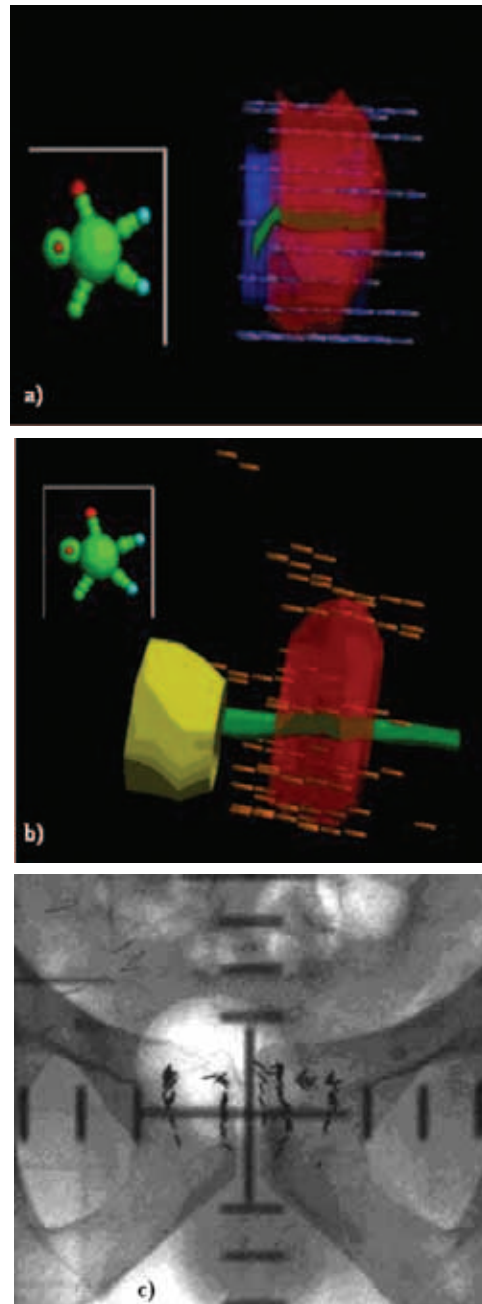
Distribution of seed types sources in: a) Pre-planned volume study, b) post plan CT, and c) post implant X-ray indicating bunching of sources.
